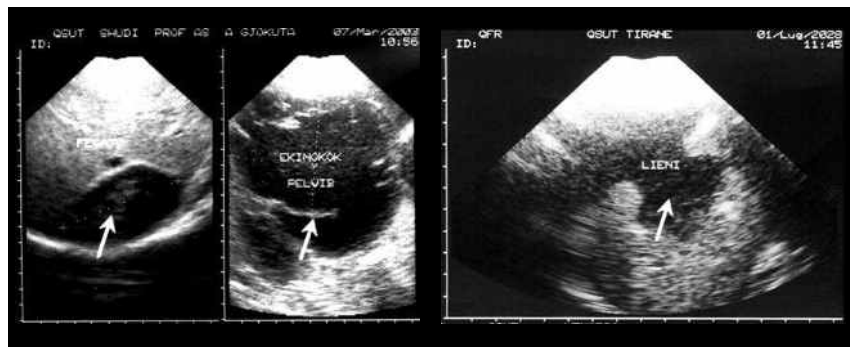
a) Ultrasound images of Alveolar echinococcosis form with its localization in the liver and ovalium. Arrows. The case is operated and the diagnosis confirmed by surgery Dr.A. Gjata. b) On ultrasound examination it is evidence the hypoechoic formation with anterior localization of Shtlien, posterior diaphragm with lung fistulization in the pulmon base (ultrasound array diagnosis), in the operation resulted Alveolar echinococcosis form with fistulization in pulmon. The case is operated and the diagnosis confirmed by surgery Dr.M.Kaçi
